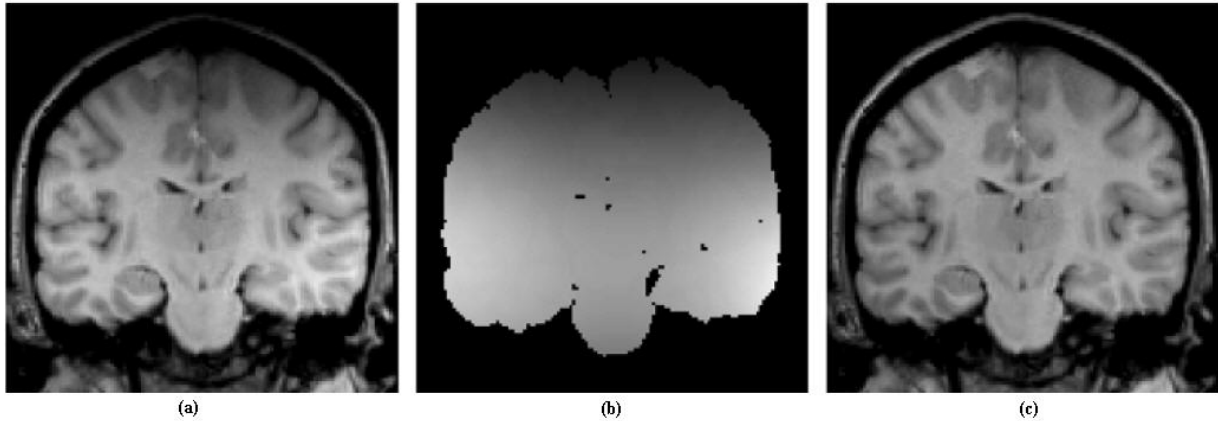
Example of the Intensity inhomogeneity issue in a MRI image (Vovk et al., 2007)
